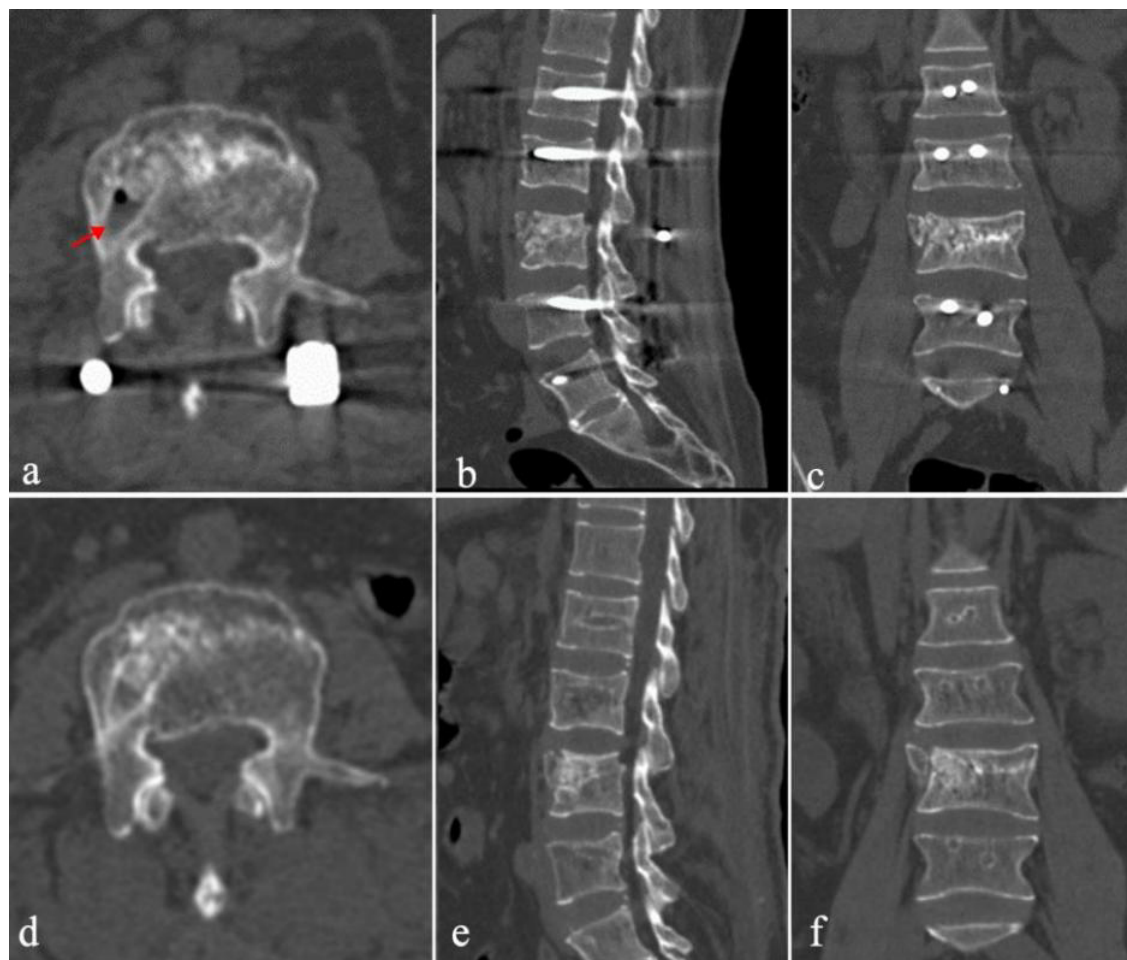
Repeat CT after spinal endoscopic bone grafting. (a-c) The postoperative review 2 days later showed adequate bone grafting in the lumbar 3 vertebral body “shell”, and the red arrow represents the bone graft channel. (d-f) At 9 months postoperatively, the CT examination showed bony filling in the “shell” of the lumbar 3 vertebrae, sclerosis of the border between the implant particles and the “shell”, and the lumbar 3 vertebral fracture healed bony, and the internal fixation device of the lumbar nail-rod system was surgically removed vertebral body.
